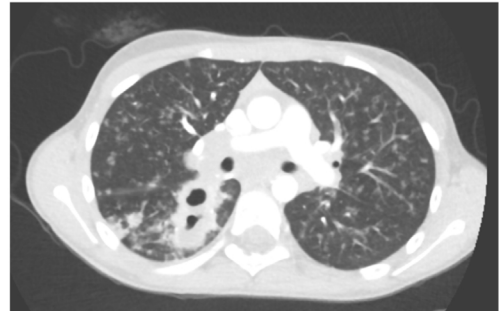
Thoracic computed tomography: disseminated tuberculosis.
